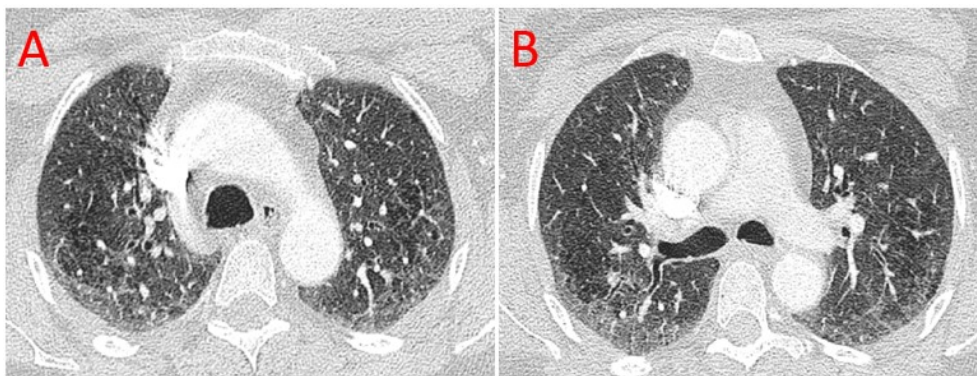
High resolution CT dicom's from a patient with desquamative interstitial pneumonitis from the ILD-PH cohort.
